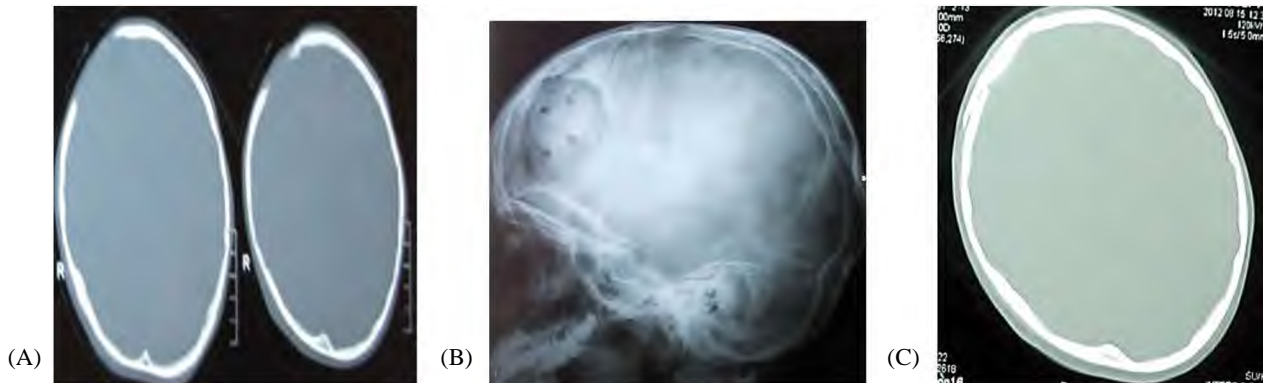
(A) The bone window of CT brain axial cuts showing right frontal skull defect. (B) X-ray skull lateral view showing closure of the defect with acrylic “ the created holes in the acrylic plate are appearant” (C) Post-operative CT after cranioplasty.
